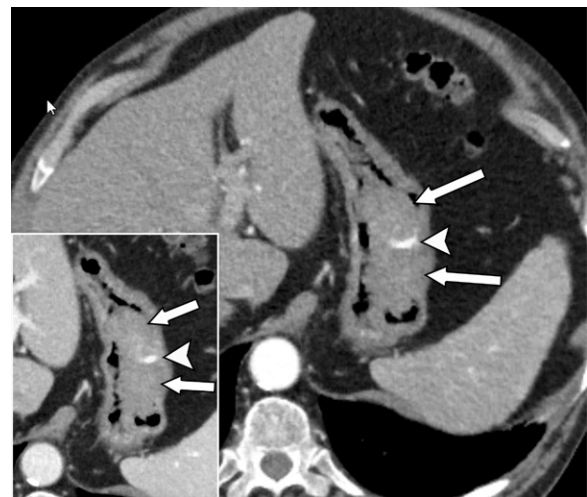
Gastric carcinoma in an 80-year-old man with weight loss and anemia. Axial arterial phase (main image) and portal venous phase (inset) CTA images show a large polypoid mass in the stomach (arrows), with adjacent contrast extravasation in the arterial phase (arrowhead in main image), which changes in size, attenuation, and shape in the portal venous phase (arrowhead, inset image). Figure E3 is an endoscopic image in this patient that shows a large gastric mass with an area of hemorrhage. Endoscopic biopsy results confirmed moderately differentiated adenocarcinoma.
